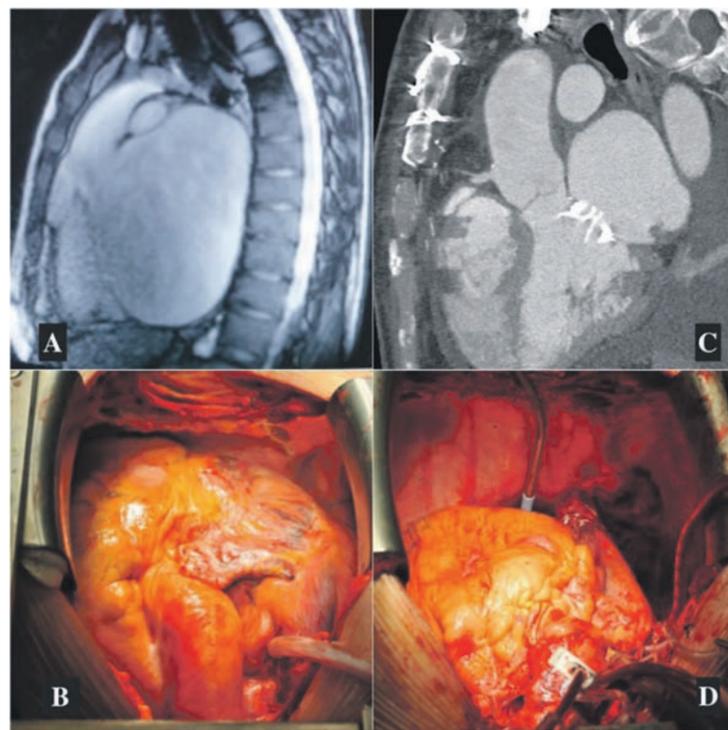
CT (A), MRI (C) and intraoperative photos (A and D) of the heart prior to the surgery (A and B) (LA volume – 1620 ml) and after the surgery (C and D) (LA volume – 482 ml) using autotransplantation technique.
